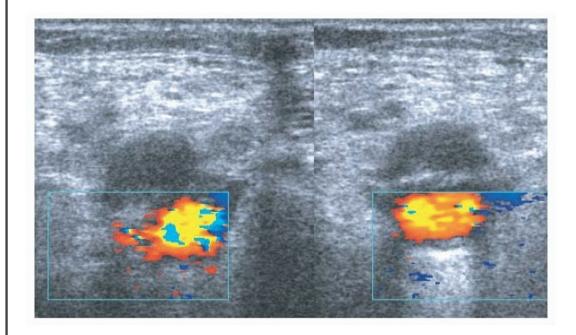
A duplex ultrasound showing a transverse view of the popliteal vein and artery, with (right) and without (left) compression. The vein (more superficial) is not collapsing under compression—a finding suggestive of DVT.
